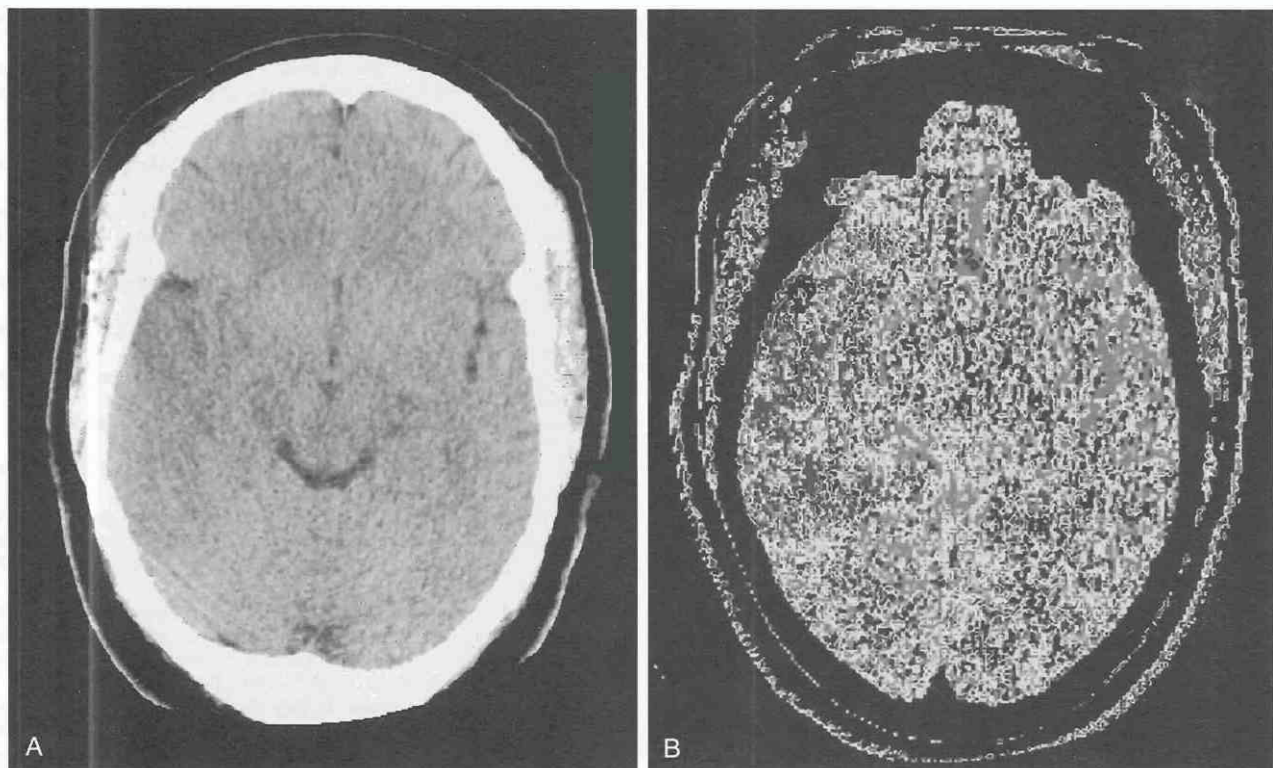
Acute stroke of the right middle cerebral artery. A, Unenhanced axial CT scan of the brain shows no substantial abnormalities. B, Mean transit time (MTT) map from dynamic CT perfusion scan depicts a well-defined region of MTT prolongation. The extent and degree of regional hemodynamic abnormalities can be determined by perfusion imaging techniques.
